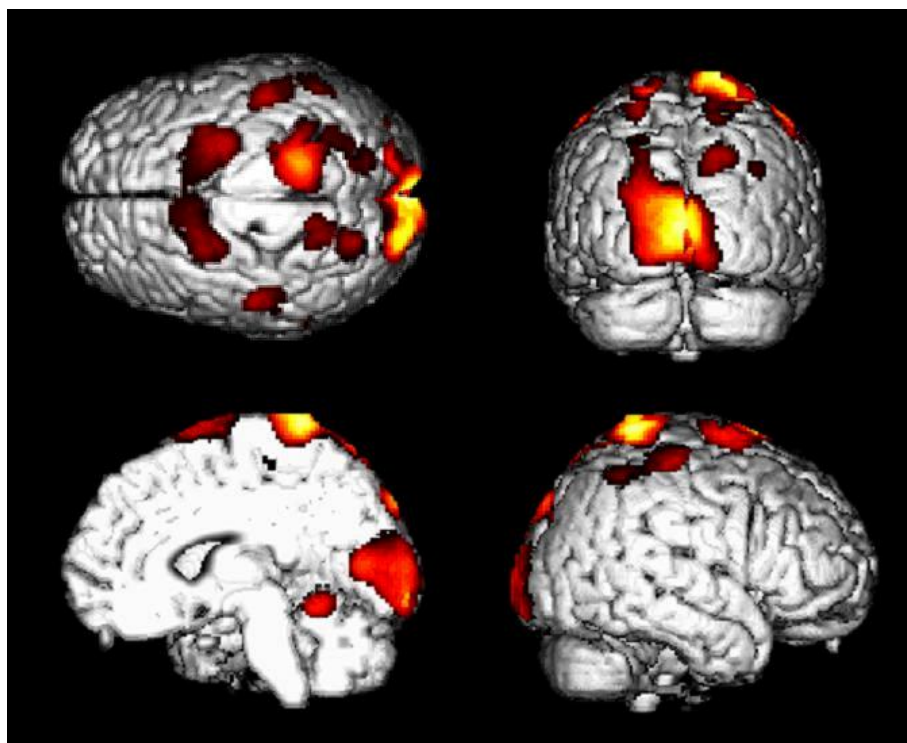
Results of [<sup>18</sup>F]FDG PET study using a running task in the up-right posture in healthy volunteers.
